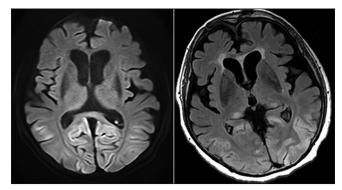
Magnetic resonance imaging brain on day 2
